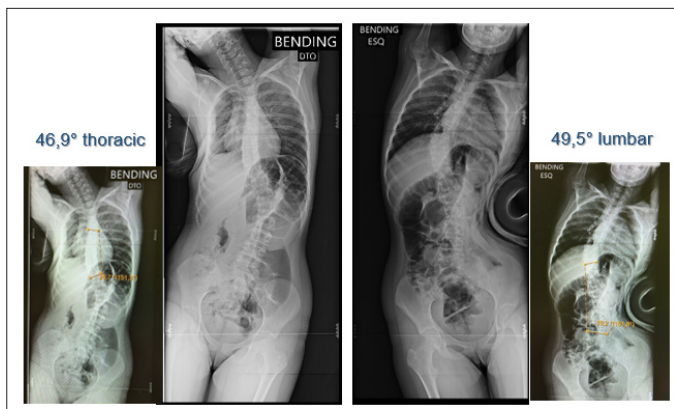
Dynamic Radiographs to test curve flexibility
